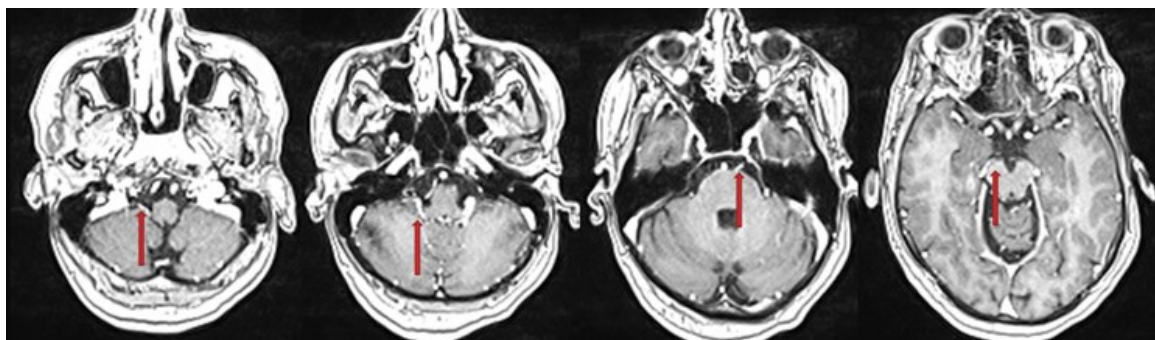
Brain MRI demonstrated contrast enhancement of cranial nerves.
